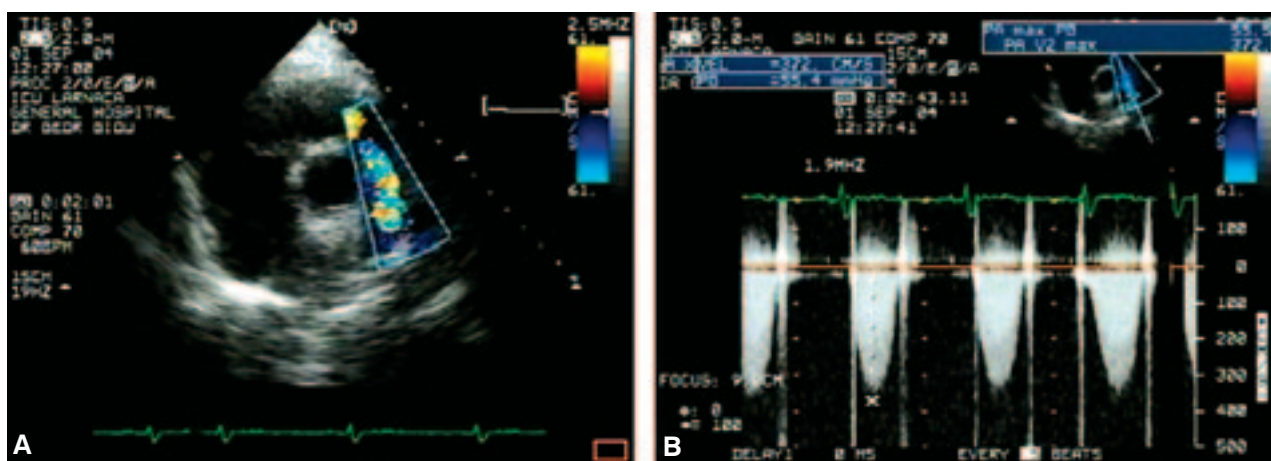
Transthoracic echocardiogram color-2D (A) and continuous-wave Doppler (B) in short axis parasternal view showing turbulent flow within the tubular part of the homograft and significantly increased flow velocity, which was compatible with a peak systolic gradient of 55 mmHg.
